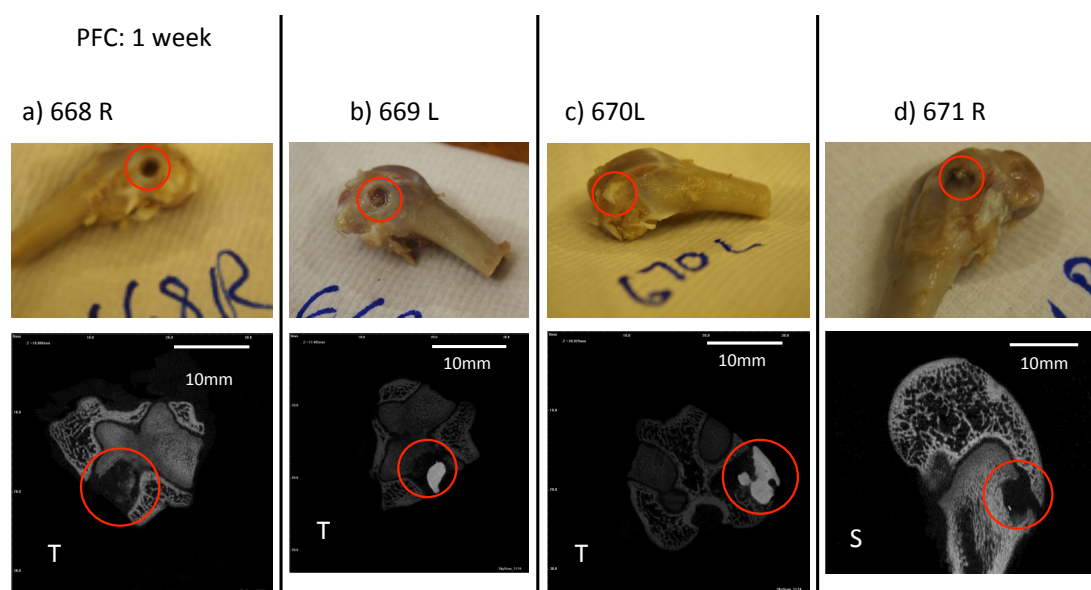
PPGDMA Micro CT images after one week in vivo. Material visible in 669L and 670L. Defect visible in 668R and 671R. Defect sites marked with red circles. Images marked with T and S are in the transverse and sagittal planes respectively.
